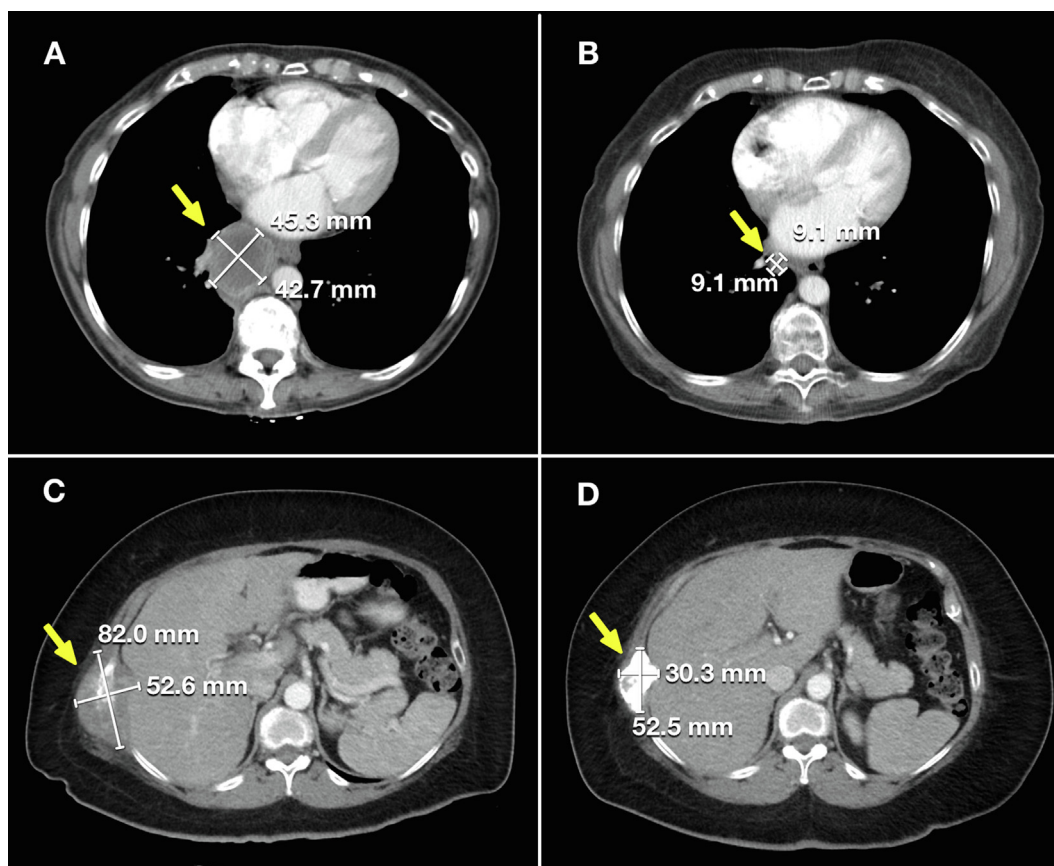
Patient 1 (A) December 2017 CT of right pulmonary nodule, (B) December 2018 CT of drastic decrease in right pulmonary nodule size following pembrolizumab therapy. Patient 2 (C) March 2018 CT showing sclerotic rib lesion, (D) April 2019 CT showing decrease in its size following radiation therapy and pembrolizumab therapy.
